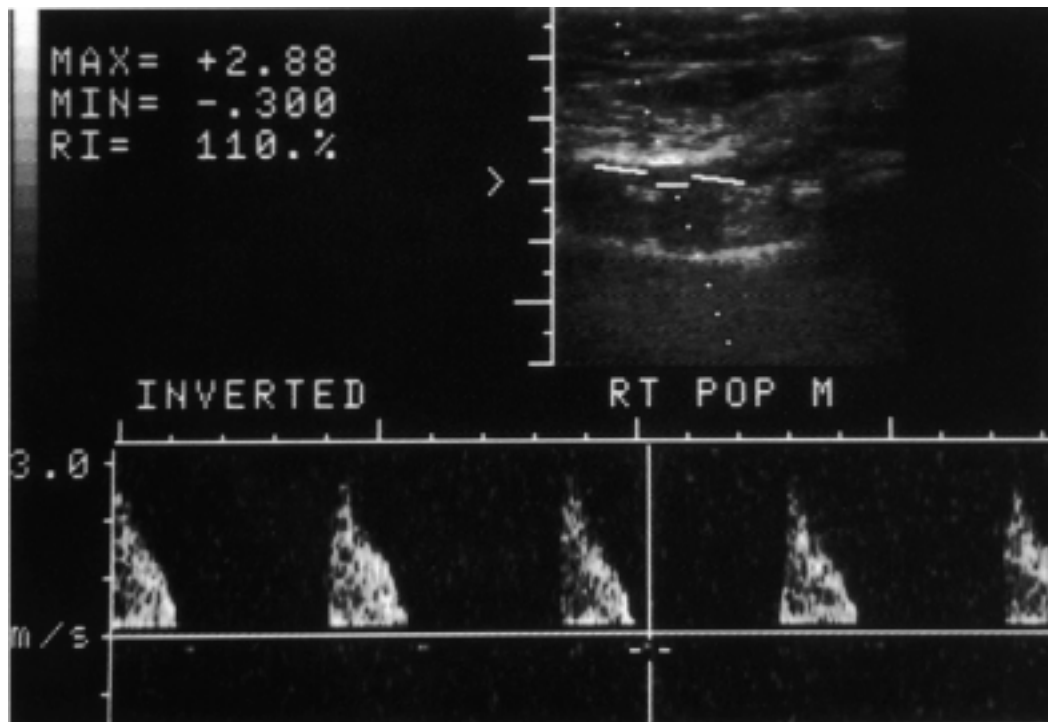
Example of the output image of a Duplex scanner from a popliteal artery with a 70% stenosis (from [Polak 1995]). Top right is a longitudinal image of the vessel and surrounding tissue. The dotted line indicates the ultrasound beam axis, the two solid lines crossing this the extent of the sample volume and the remaining solid lines the vessel axis markers. The spectrogram of the Doppler signal is displayed at the bottom of the figure.
